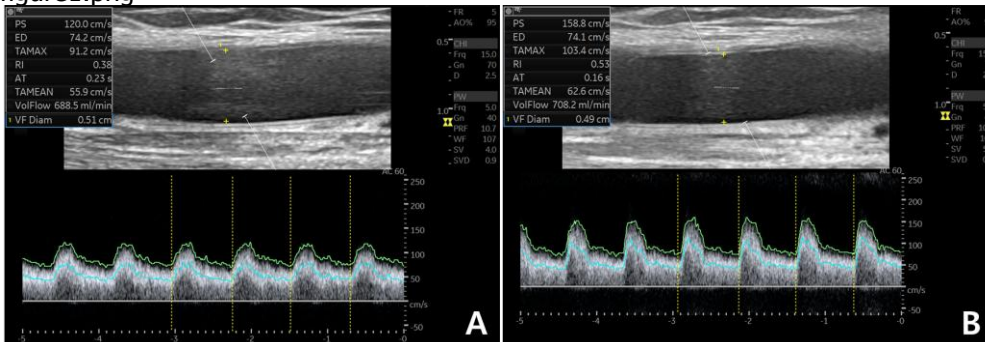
(A) Pulsed-wave (PW) Doppler ultrasound of the brachial artery demonstrates a delayed acceleration time of 0.23 seconds. (B) Following stent deployment for the subclavian artery stenosis, the acceleration time is improved to 0.16 seconds.
